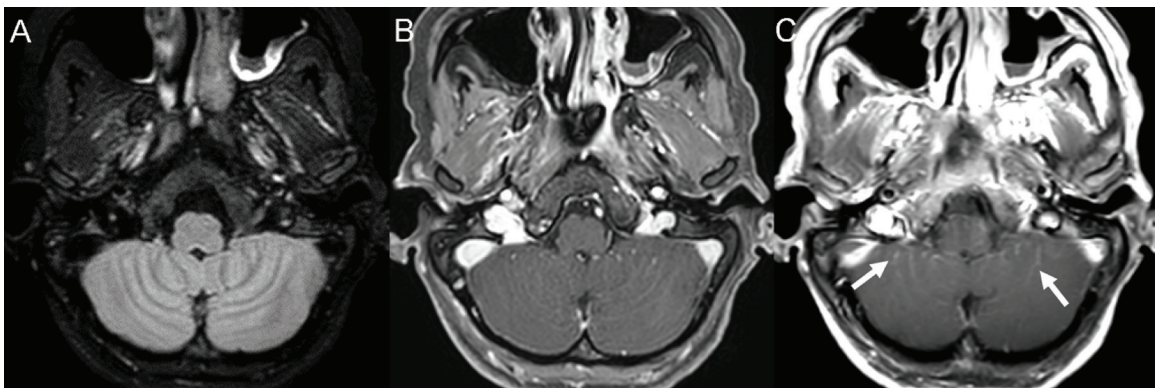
A 49-year-old woman with herpes simplex virus meningitis. (A) Axial CE-3D FLAIR/FS and (B) CE-3D THRIVE showed no leptomeningeal enhancement or subarachnoid space abnormality along cerebellar folia, while (C) axial CE-T1WI showed leptomeningeal enhancement along bilateral cerebellar folia (arrow).
